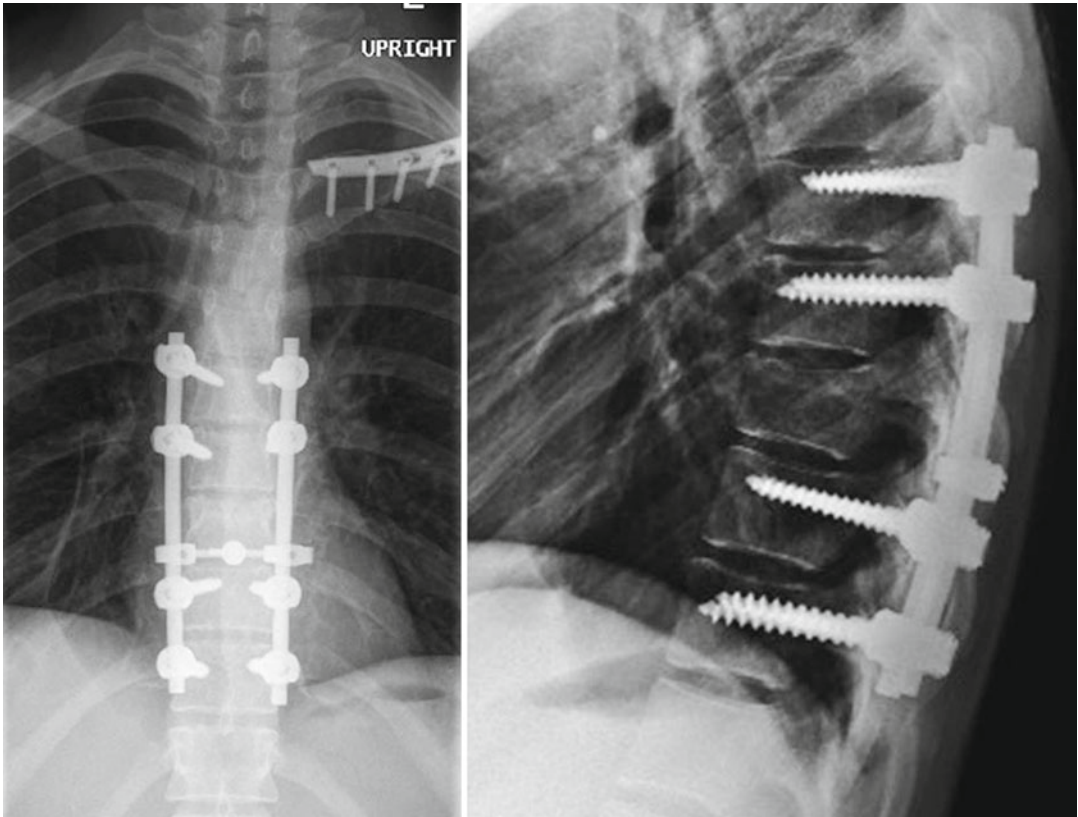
Postoperative anteroposterior and lateral X-ray images of the thoracic spine showing T7–11 open reduction and internal fixation with instrumented posterior spinal fusion for the T9 “Chance fracture.” Notice the image is taken with the patient upright. The immediate spinal stability provided by the procedure enables early mobilization and proper nursing care. It also obviates the need
